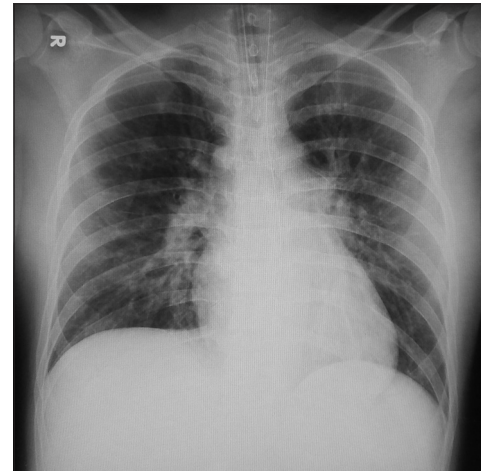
Chest X-ray, anteroposterior view, showing diffuse infiltrates bilaterally in the lung field indicating pulmonary edema
